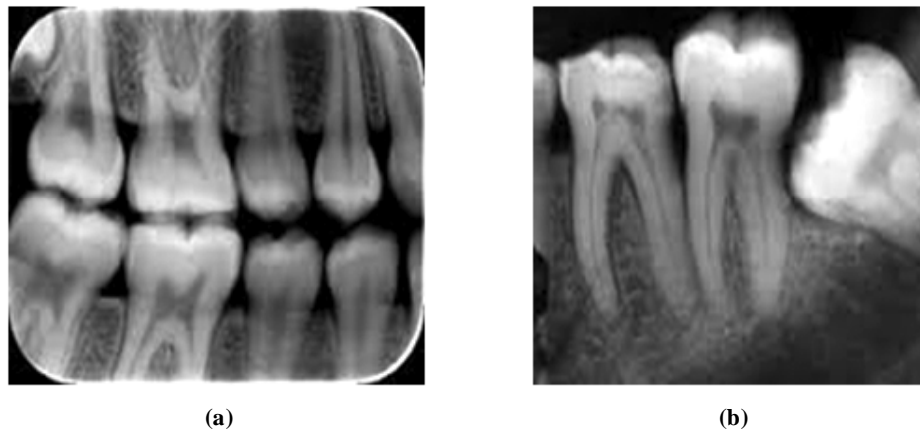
(a) Bite-wing x-rays (b) Periapical x-rays [1]
